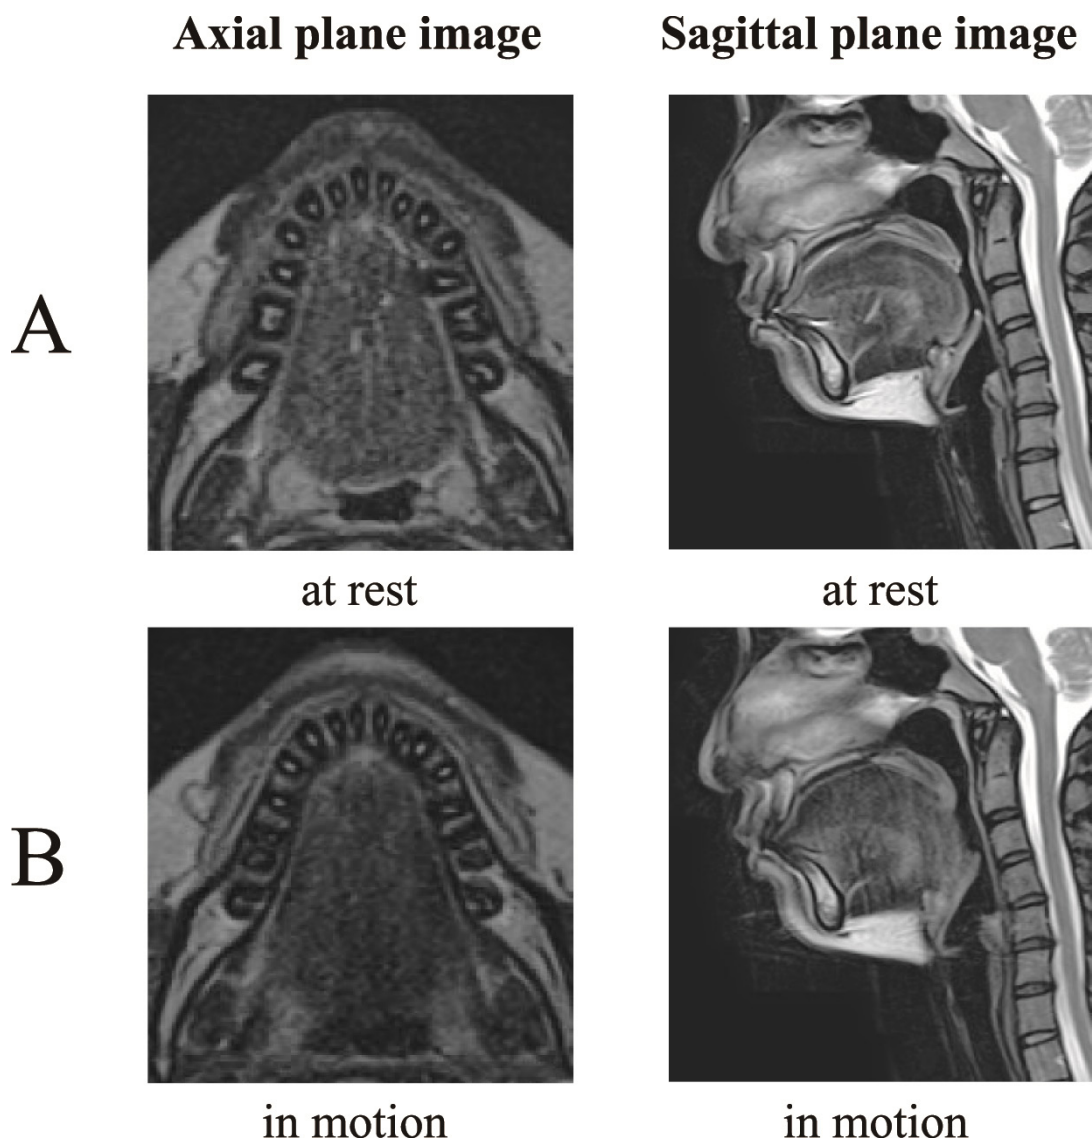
MR image of the tongue at rest (A) and in motion (B)
